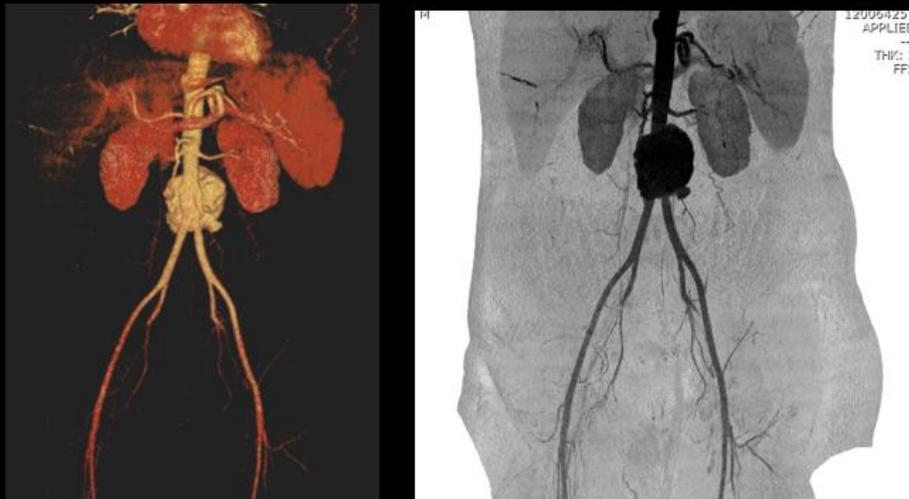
A CT aortic angiography 3D rendering large saccular wide neck aneurysmal dilatation of the abdominal aorta originate distal to the origin of the renal arteries.
